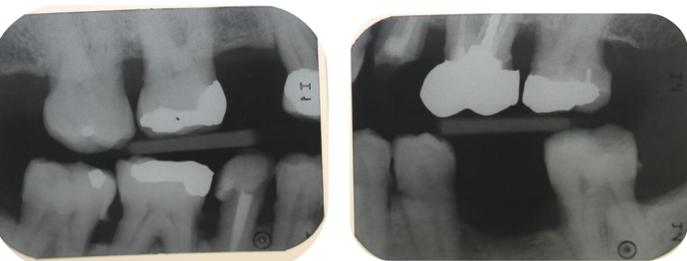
Bitewings taken 1 year previously
